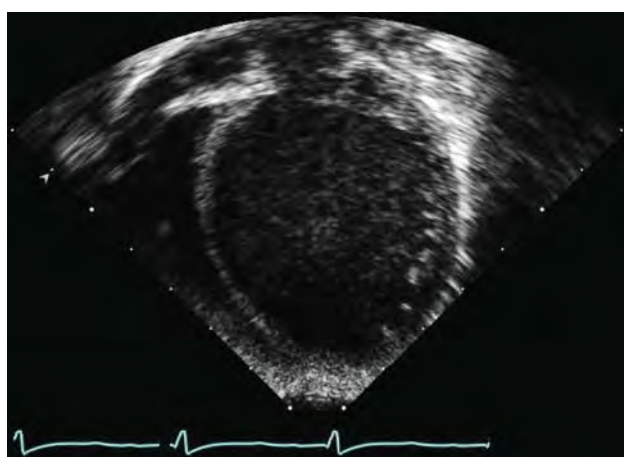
Echocardiography: four-chamber view obtained from a 1-month-old female presenting with poor growth, tachypnea, and sweating with feeds. The estimated ejection fraction was 15%. Note the marked LV enlargement. The patient's left atrium was also severely dilated.
